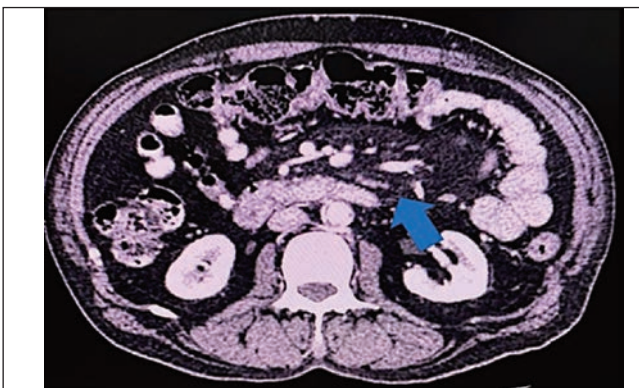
CT scan of the abdomen with contrast axial view of Case no. 4 showing significant fat stranding within the mesentery in the mid and left side of the abdomen with few sub-centimetre lymph nodes.
